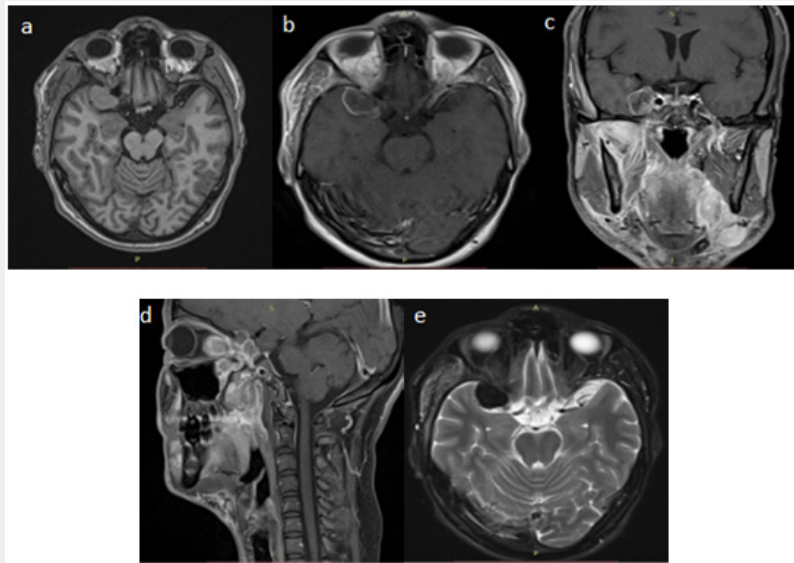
Preoperative MRI demonstrating a sharply margined extra axial temporal mass with relatively homogeneous contrast enhancement and extends to the sella turcica and to the sub-temporal fossa (a) T1-weighted image, (b,c,d) T1-weighted image with gadolinium contrast on transverse, coronal and sagittal section, (e) T2-weighted image.
